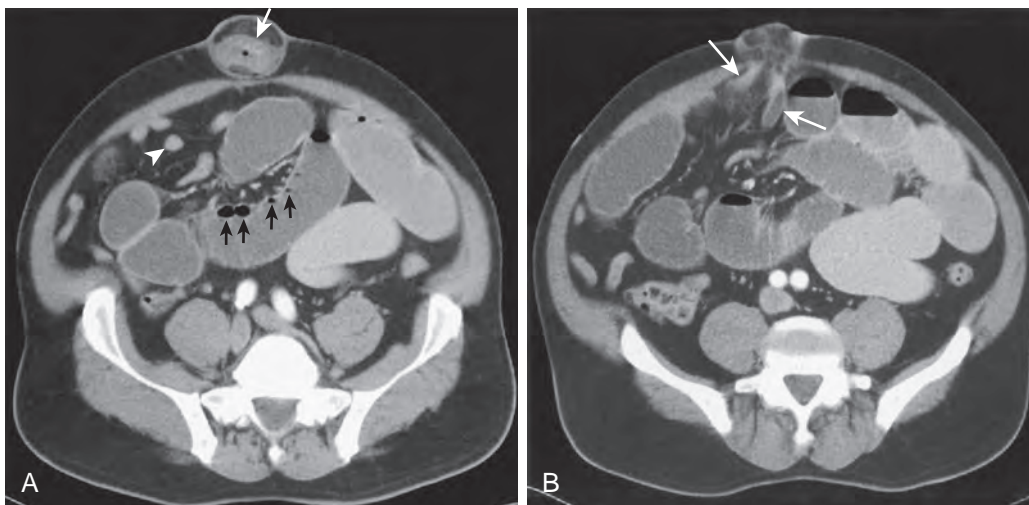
CT scan demonstrating umbilical hernia resulting in small bowel obstruction and strangulation.
